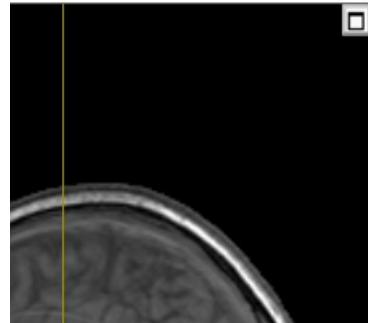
Click the box to enlarge the MR image
